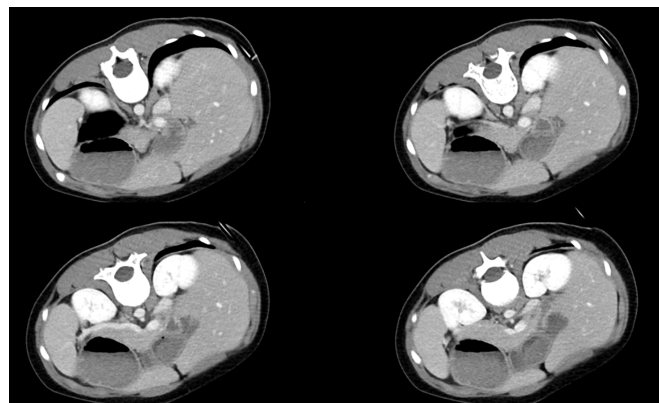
CT scans showing the location of the pencil.
